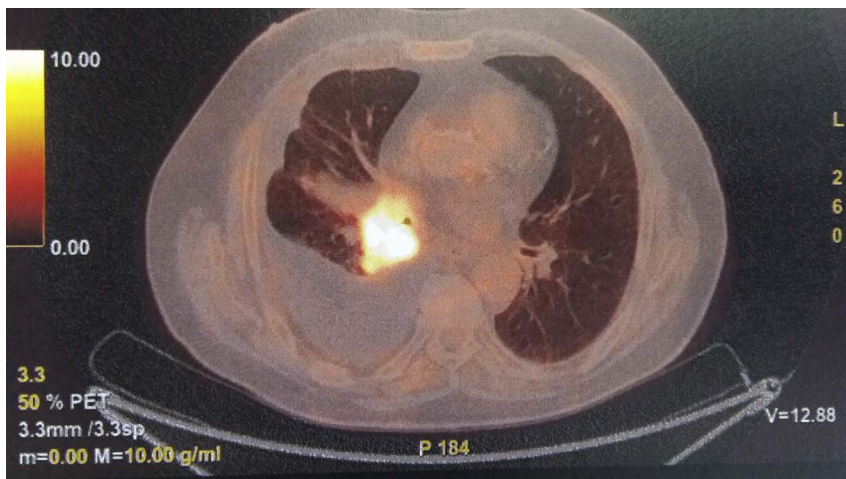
PET-CT slice presenting the mass in the right lower lobe with pleural effusion.
